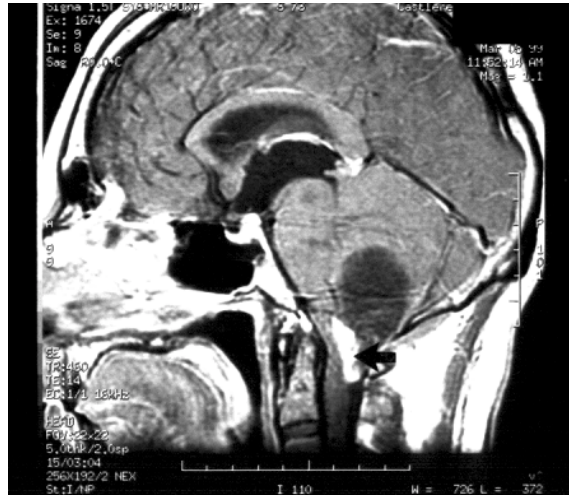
Enhanced sagittal T1 W MR image of the brain taken in the midline.
